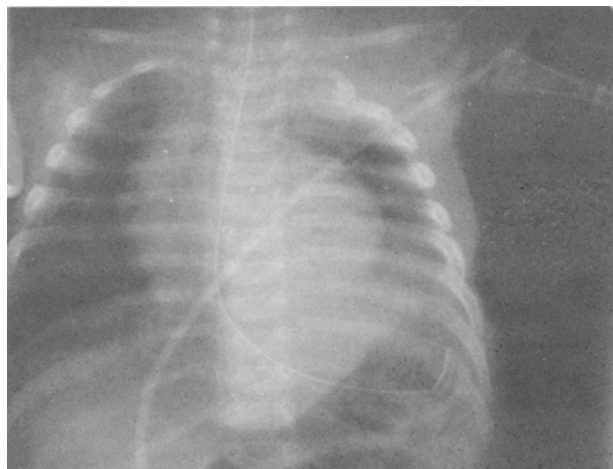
Chest radiograph showing elevated left dome of diaphragm.
